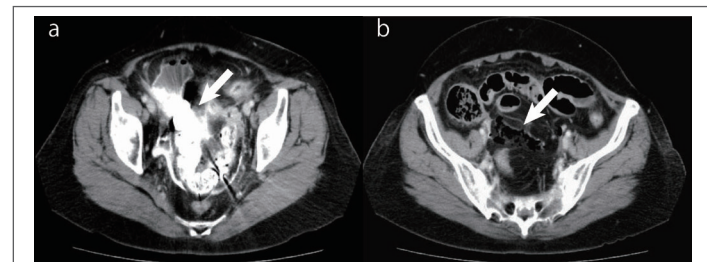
Abdominal computed tomography at admission for a 72-year-old woman with perforation of the large intestine after upper gastrointestinal series with barium: a) A 3-cm barium stool (arrow) is noted in the sigmoid colon, with barium leakage and free air surrounding the stool; b) Free air is observed in the pelvis (arrow).
